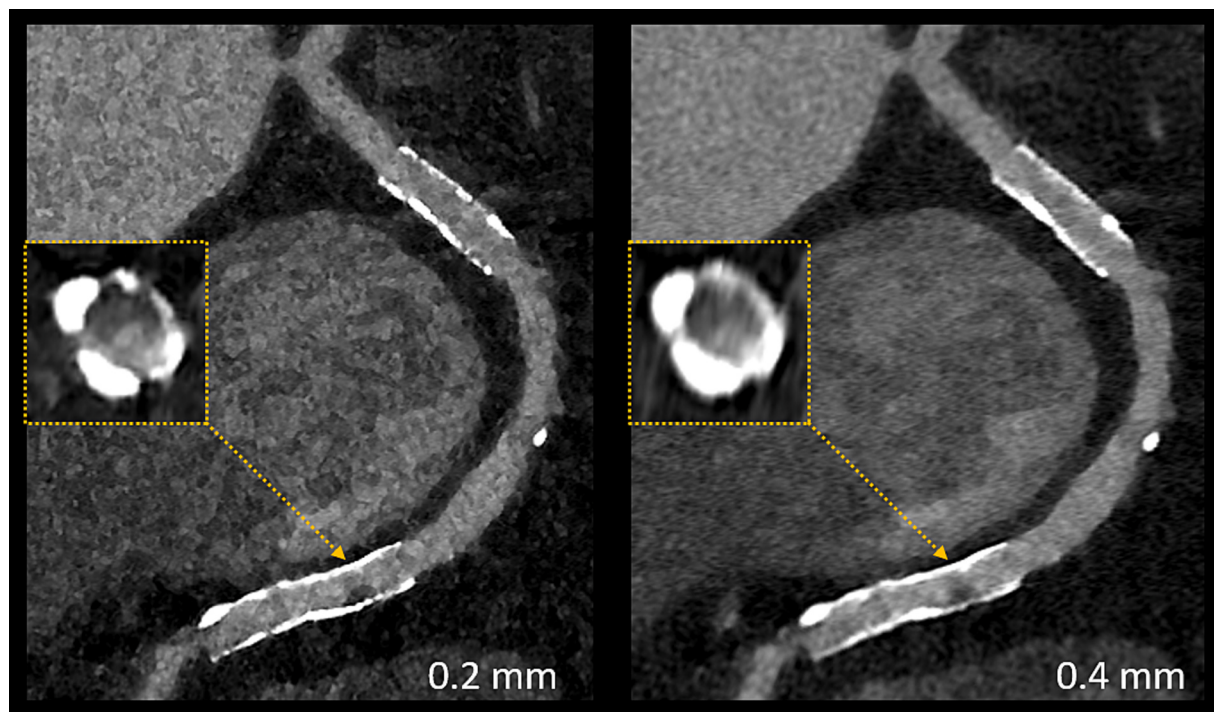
Ultrahigh-resolution photon-counting detector CT for identifying in-stent restenosis. Comparison of 0.2 mm and 0.4 mm reconstructions in a stented coronary segment of the RCA. The UHR (0.2 mm, Bv64) image demonstrates markedly reduced blooming artifacts and sharp delineation of the stent lumen, leading to classification as non-obstructive ISR. In contrast, the 0.4 mm reconstruction overestimates the luminal narrowing, resulting in an obstructive classification. Invasive coronary angiography confirmed the non-obstructive nature of the lesion. Abbreviations: ISR: In-stent Restenosis; PCD-CT: Photon-counting Detector Computed Tomography; UHR: Ultrahigh-resolution.
